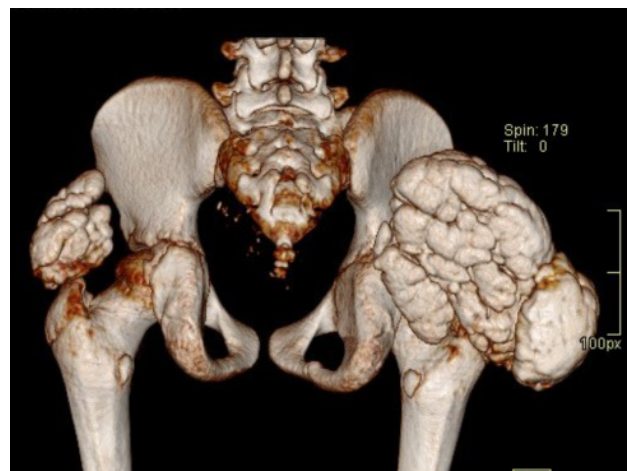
Preoperative 3D CT scan shows juxta articular bilateral Trochanteric lobulated, mass.
